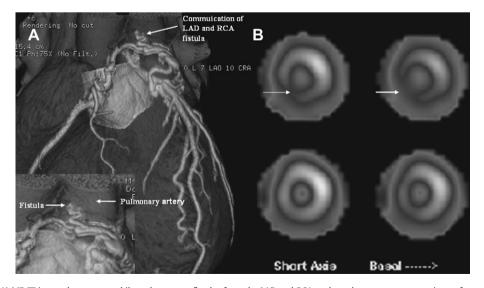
MDCT and SPECT: (A) MDCT image demonstrates bilateral coronary fistulas from the LAD and RCA to the pulmonary artery merging to form an aneurysm (white arrow) before entering the pulmonary artery (inset bottom left: pulmonary artery and fistula); (B) myocardial perfusion imaging studies showing a reversible perfusion defect (white arrow) over the inferior wall and part of the apical wall. LCA = left coronary artery; MDCT = 64-slice multidetector computed tomography; RCA = right coronary artery; SPECT = thallium²⁰¹ single-photon emission computed tomography.
